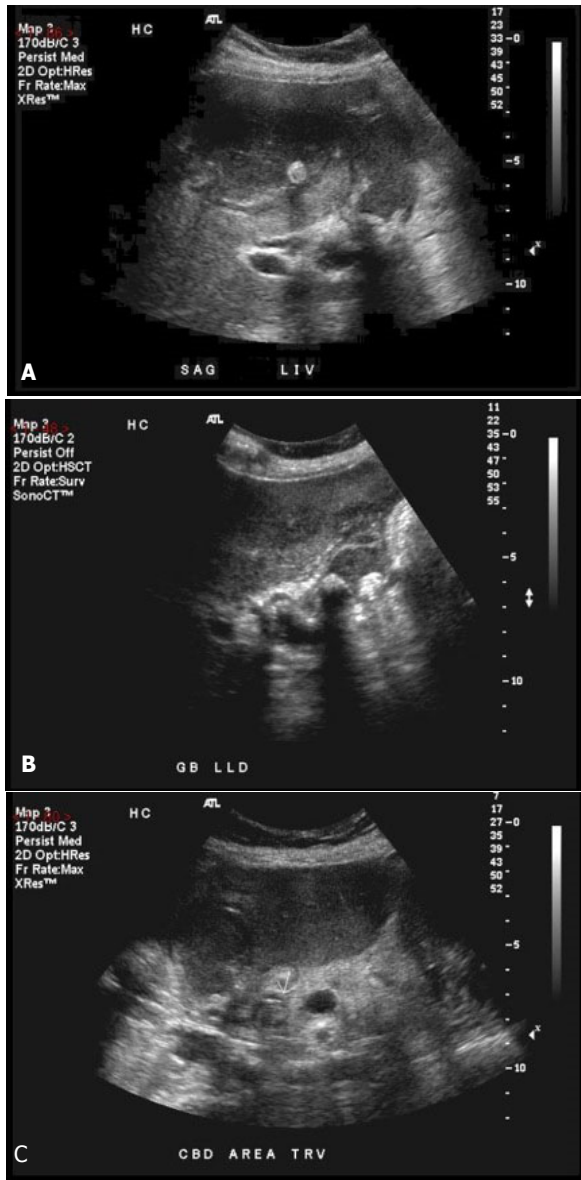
Sonography of a 67-year-old woman with gallstone liver abscess. A, The left hepatic lobe demonstrates hypoechoic abscess with focal echogenic gallstone internally. B, The gallbladder contains several echogenic calculi with posterior acoustic shadowing. C, There is an echogenic gallstone filling the common bile duct.
